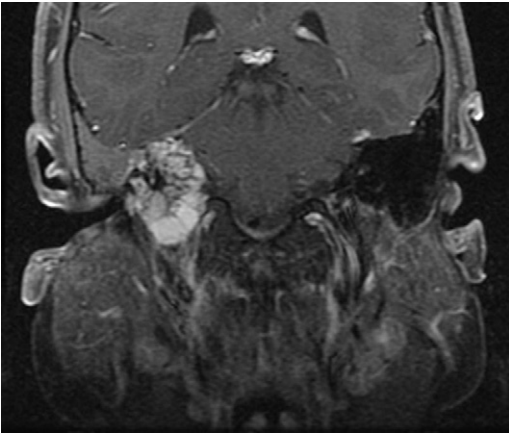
Coronal T1 enhanced MRI of large right endolymphatic sac tumor showing tumor largely contained by the dura. (From the Department of Head and Neck Surgery, MD Anderson Cancer Center; with permission.)
